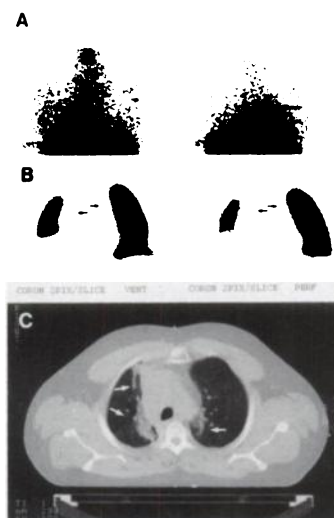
(A) Anterior and posterior planar  $^{111}\text{In}$ -pentetreotide images of Patient 4 shows intense bilateral abnormal uptake in lung areas which were included in mediastinal irradiation for a malignant lymphoma. On SPECT images (B), concentrates  $^{111}\text{In}$ -pentetreotide uptake in both superficially and deeply located lung areas (arrows).
